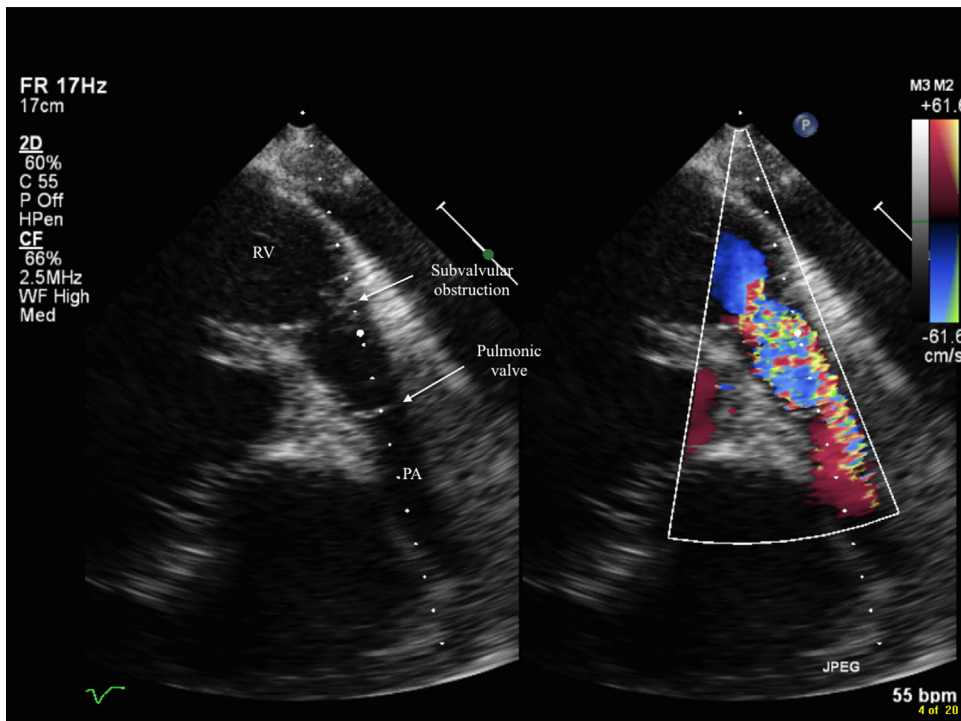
Preoperative transthoracic parasternal long-axis RV outflow view with 2D (left) and color-flow Doppler (right) demonstrating the subvalvular obstruction in the RVOT. PA, pulmonary artery; RV, right ventricle; RVOT, right ventricular outflow tract.
